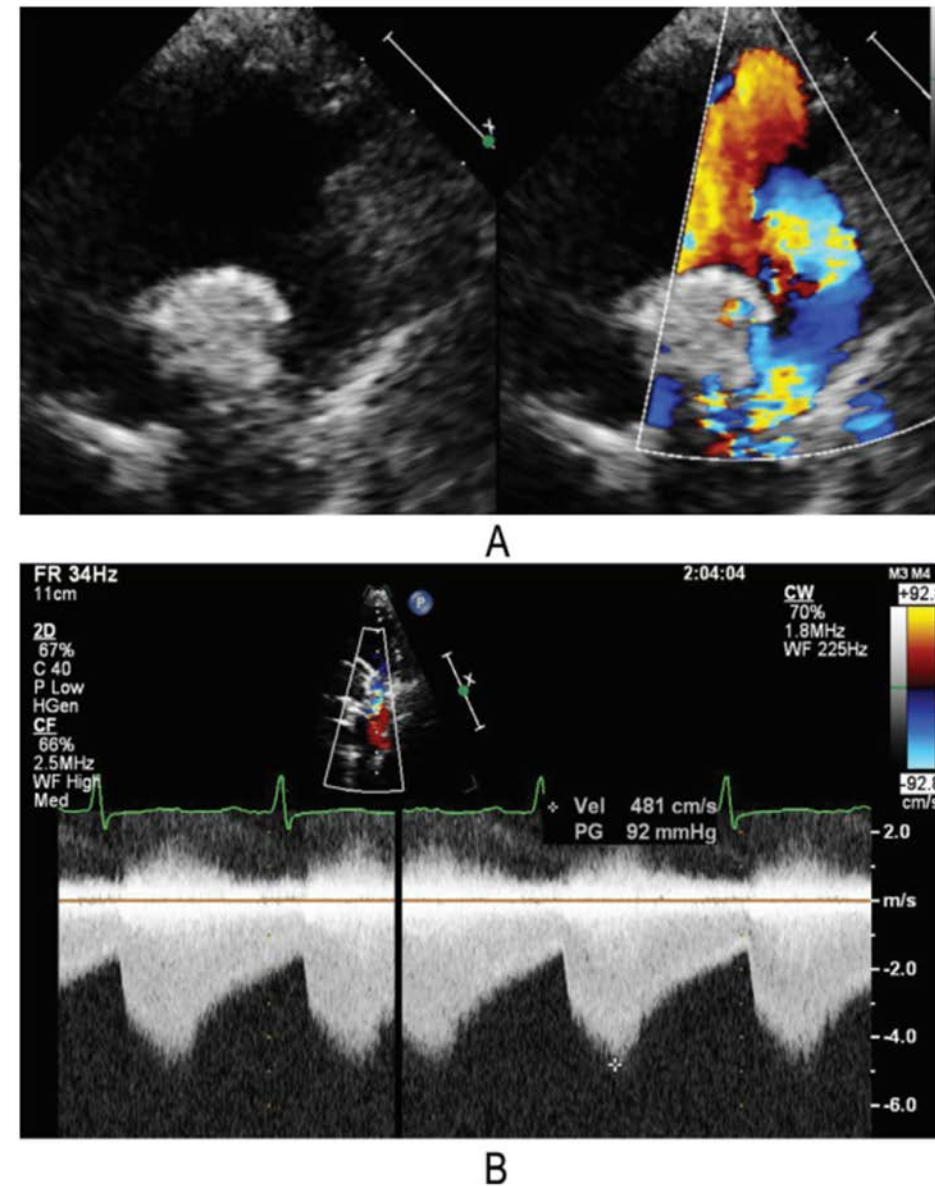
(A) 2D echo with color flow doppler showing severe narrowing of the proximal descending aorta with significant turbulence and a peak velocity of 4.8 m/s consistent with severe aortic coarctation. (B) Doppler tracing shows delay in return to baseline in diastole (diastolic drag) and blunting of the abdominal aortic doppler pattern consistent with significant aortic coarctation.
